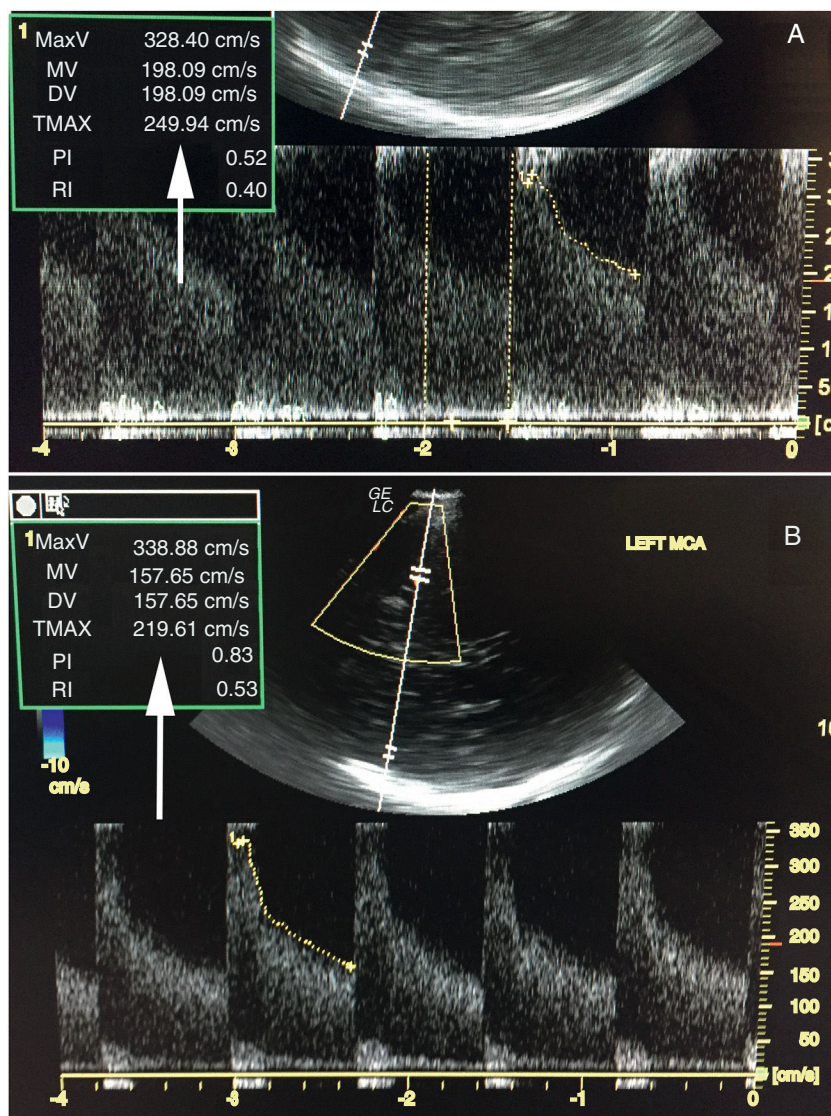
Measurement of mV in left MCA. TCD ultrasound before the block (A) and after the block (B).
